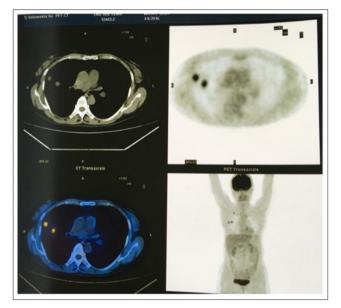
PET-CT imaging showing two lung metastases 10 months following chemo and radiation treatments of the pelvic primary tumor and metastases. Note the lack of pelvic recurrence.
